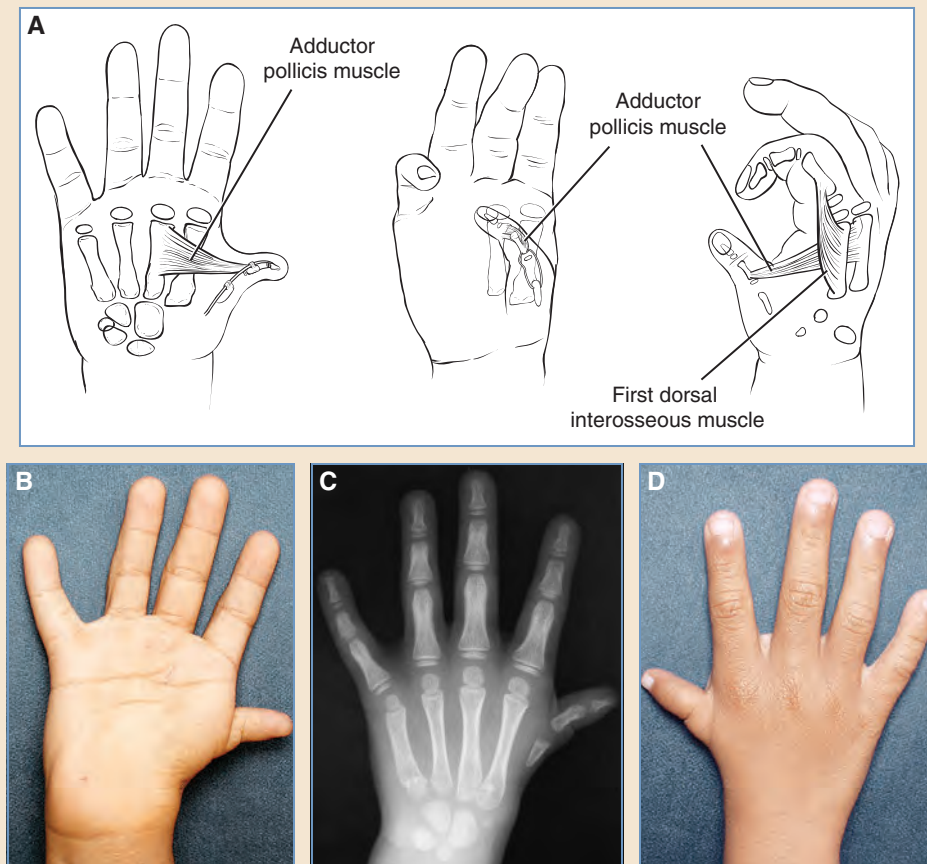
Type IIIB thumb hypoplasia. A, The median nerve–innervated thenar intrinsic muscles are absent entirely. There is severe hypoplasia of the AddP, the FPB-lateral head, and the ulnar origin of the first DI. The CMC joint articulation of the proximal metacarpal is absent. The MP joint is very lax or absent on both radial and ulnar sides. Flexor and extensor extrinsic tendons are severely hypoplastic or absent. B-D, Clinical appearance and radiograph of a 4-year-old patient with a well-formed but functionless floppy thumb. There is no skeletal stability or extrinsic flexion or extension. Very small flexor or extensor tendons may be present and can result in some movement.
